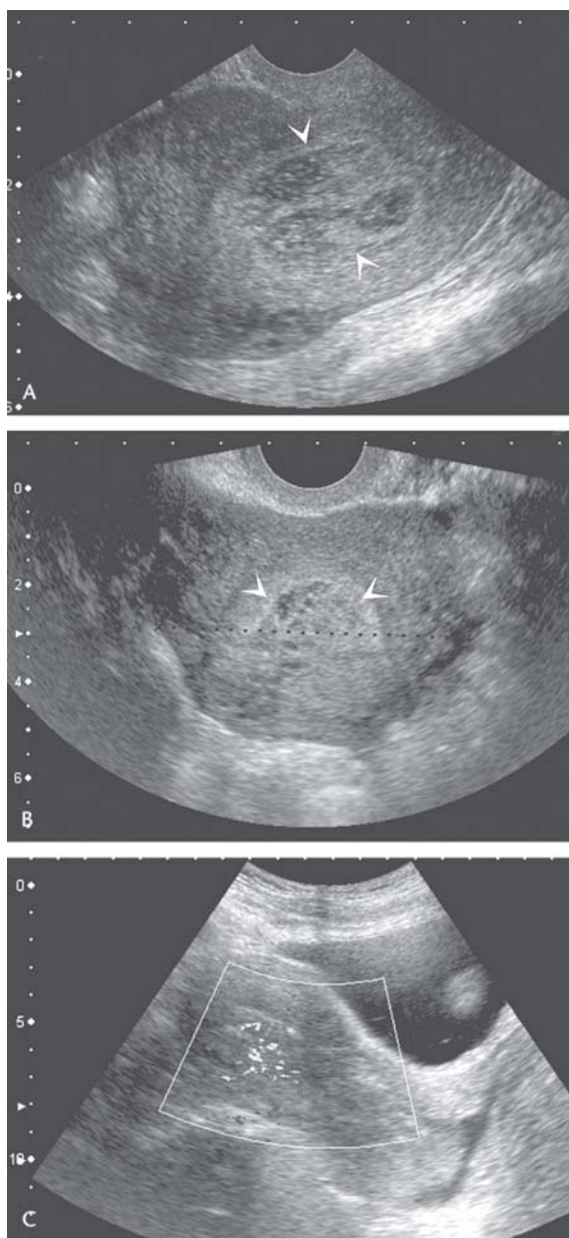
is reprinted with permission from: Dogra V, Paspulati RM, Bhatt S. First trimester bleeding evaluation. [Review] [125 refs] [Journal Article. Review] *Ultrasound Quarterly*. 21(2):69-85.
